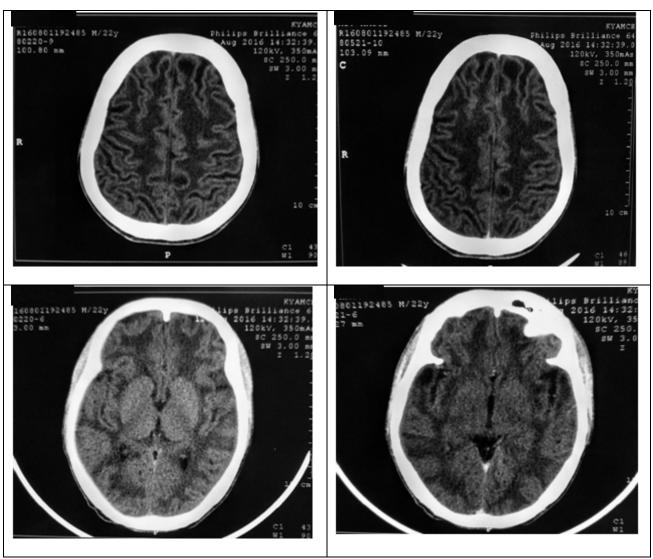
Non contrast and contrast CT of brain showing diffuse hypointensity along white matter, subcortical arcuate fibre sparing thalamus, basal ganglia with thinning of cortex and normal sized ventricles
